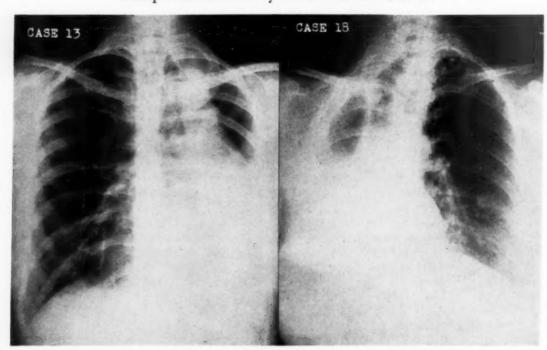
Chest roentgenograms (Cases 13 and 18) revealing herniation of the remaining lung across the mediastinum.
